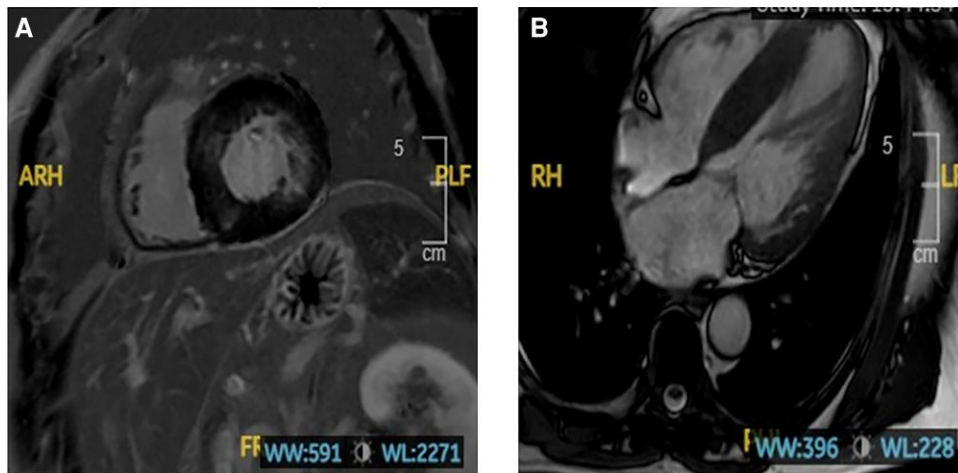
(A and B) Cardiac magnetic resonance imaging cine imaging confirming hypertrophic cardiomyopathy with predominant septal hypertrophy, with co-existing non-*ischaemic* scar on post-contrast imaging.
